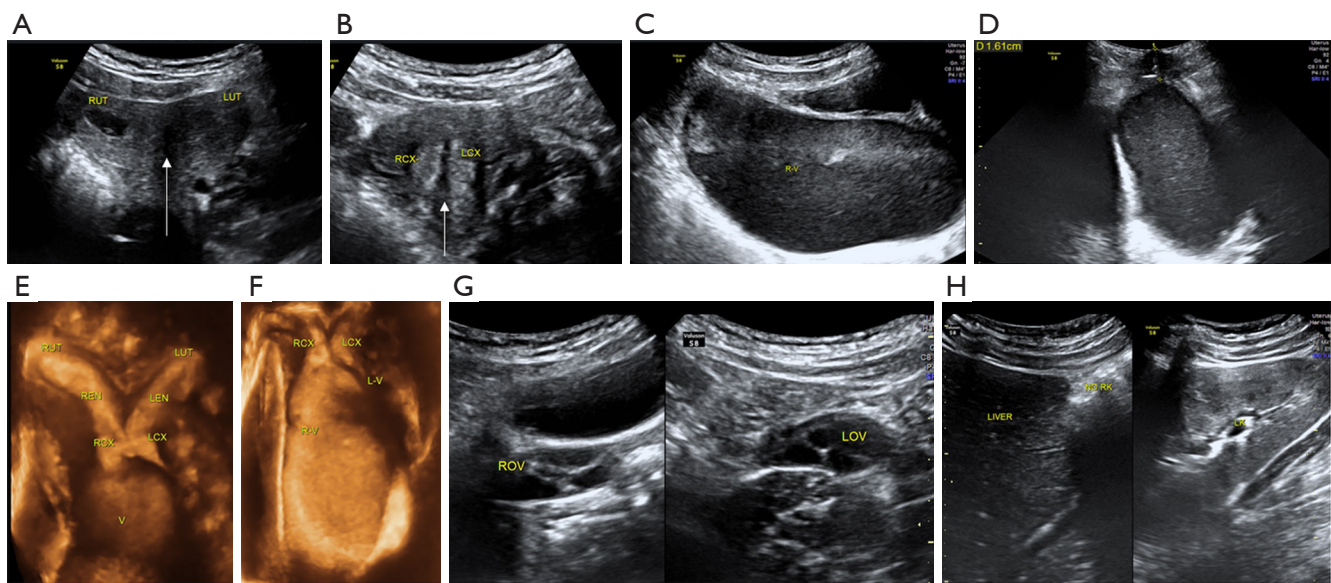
Type I-a UGTOIRA syndrome: U3c-C1-low OVS, bicorporal septate uterus, septate cervix without cervical obstruction, with right-low OVS (without communication observed intraoperatively), and right renal agenesis. Sonograms were obtained from an 11-year-old female patient. (A) TAS 2D coronal plane of the uterus demonstrating right hematometra and normal left uterus (the arrow indicates the uterine septum). (B) TAS 2D coronal plane of the cervix demonstrating the cervical septum (the arrow indicates the cervical septum). (C) TAS 2D sagittal plane of the right cervix-vagina demonstrating a large amount of hematocele in the posterior space of the OVS. (D) TPS 2D sagittal section of the perineum demonstrating that the lower edge of the right vaginal hematocele is 1.6 cm from the perineum. (E) TAS 3D coronal plane of the uterus-cervix-vagina under stereoscopy demonstrating the bicorporal septate uterus, septate cervix, and right-low OVS with a large amount of hematocele in the posterior space of the OVS. (F) TAS 3D coronal plane of the cervix-vagina under stereoscopy demonstrating the bicorporal septate cervix and right-low OVS with a large amount of hematocele in the posterior space of the OVS. (G) TAS 2D ovarian sagittal planes demonstrating both normal ovaries. (H) TAS 2D sagittal planes identifying the absence of the right kidney (NO RK; left side of the figure) and a normal left kidney (LK, right side of the figure). RUT, right uterus; LUT, left uterus; RCX, right cervix; LCX, left cervix; R-V, right vagina; REN, right endometrium; LEN, left endometrium; V, vagina; L-V, left vagina; ROV, right ovary; LOV, left ovary; RK, right kidney; LK, left kidney; UGTOIRA, unilateral genital tract obstruction with ipsilateral renal anomaly; OVS, oblique vaginal septum; TAS, transabdominal sonography; TPS, transperineal sonography; 2D, 2-dimensional; 3D, 3-dimensional; RCY, right ovarian cyst.
